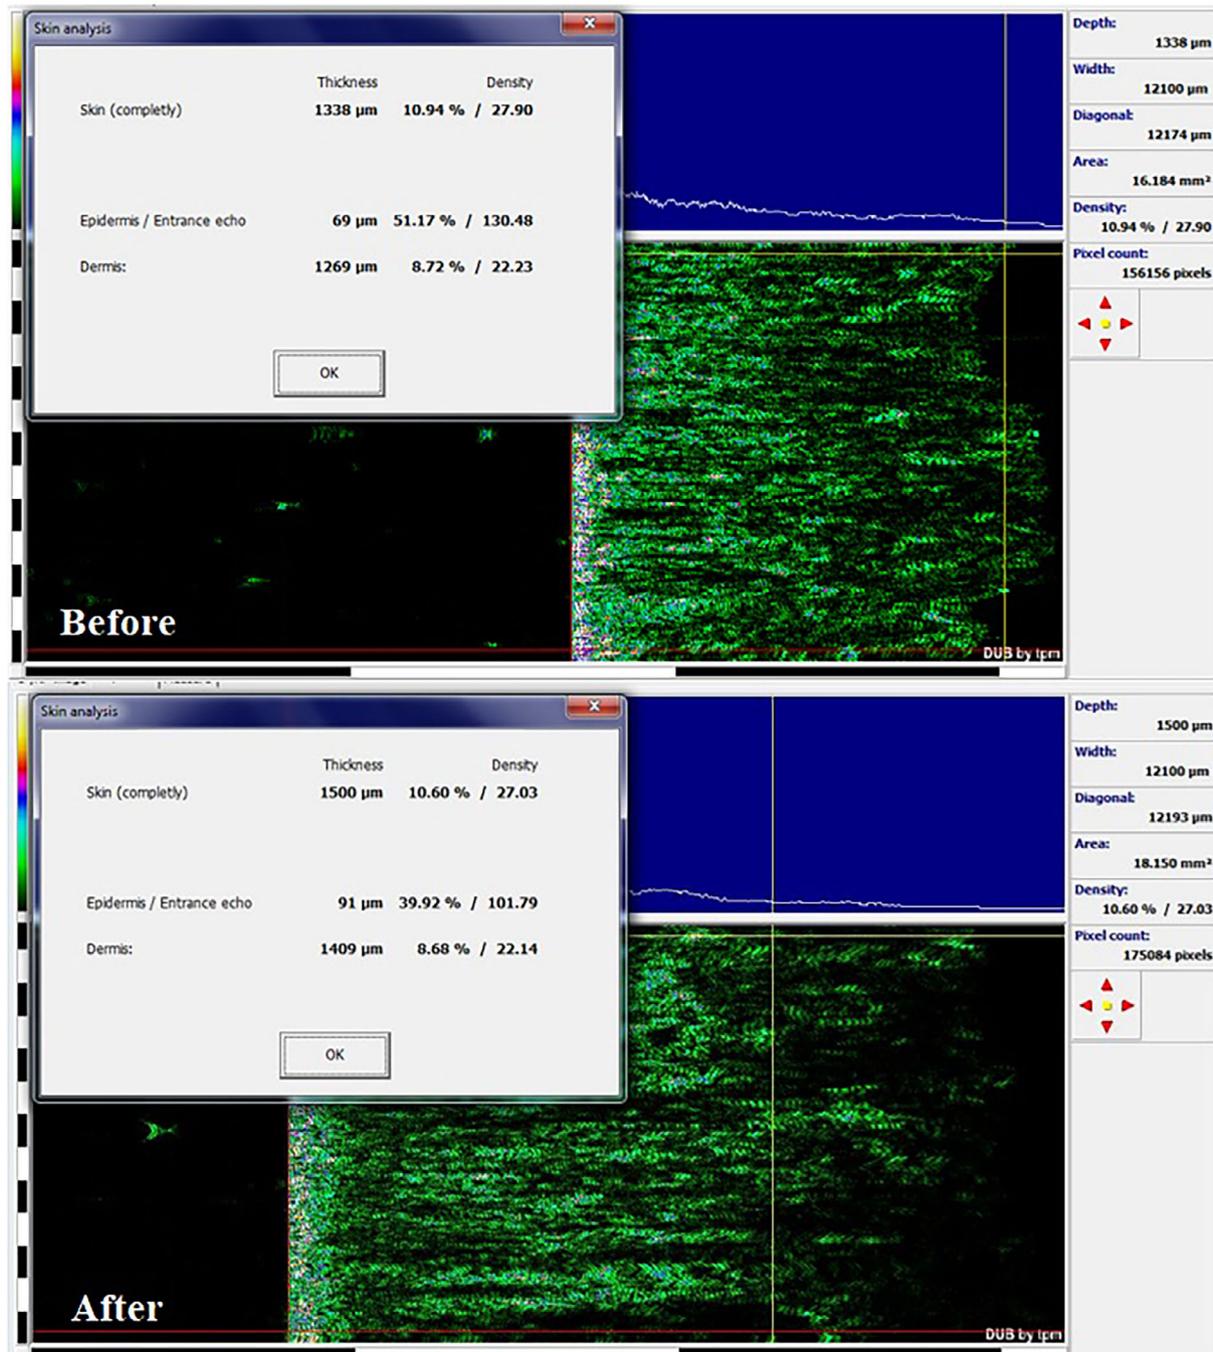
Skin analysis with ultrasonography for case A.
